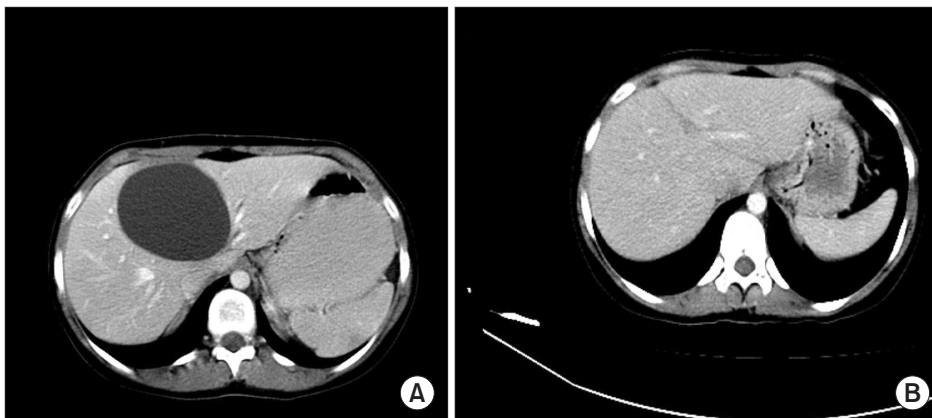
Preoperative and postoperative comparison of CT scans. (A) Preoperative CT imaging shows type 1 hydatid cyst in segment 4, sized 86 × 34 mm. (B) Postoperative CT imaging after internal capitonage shows regression of hydatid cyst in segment 4, with no signs of relapse.
